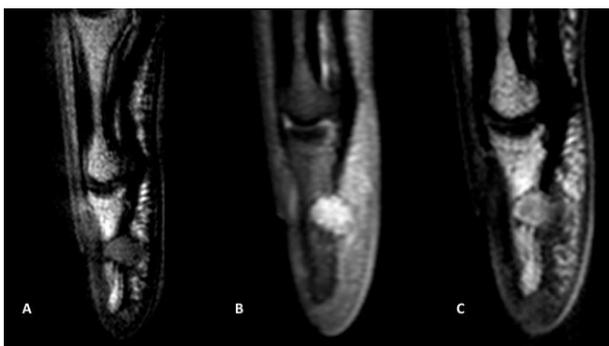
MRI of the second finger of the right hand: sagittal reconstructions in T1-w sequence (A), PD-SPAIR-w sequence (B), contrast-enhanced T1 (C). The finding is a mass hypointense in T1 weighted sequences and hyperintense in PD-SPAIR, with a thin calcific ring (A-B) and cortical bone infiltration. The lesion shows high contrast enhancement (C).
